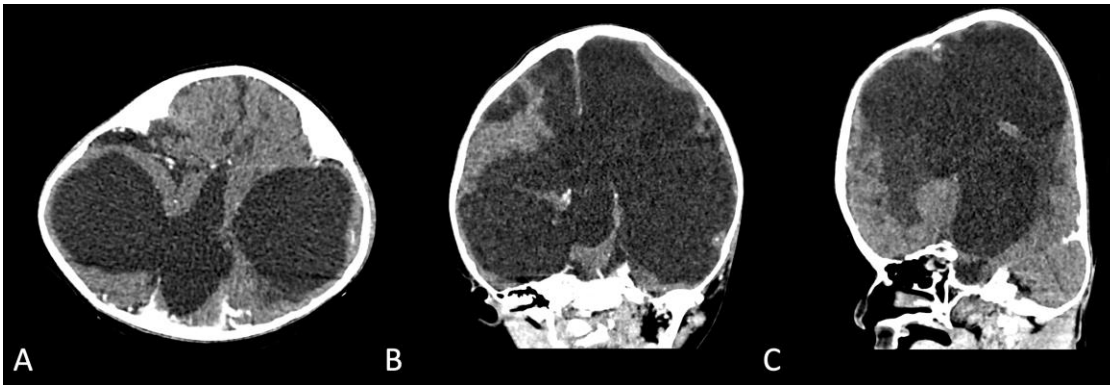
CT-scan revealed hydrocephalus on axial (A), coronal (B) and sagittal view (C)
